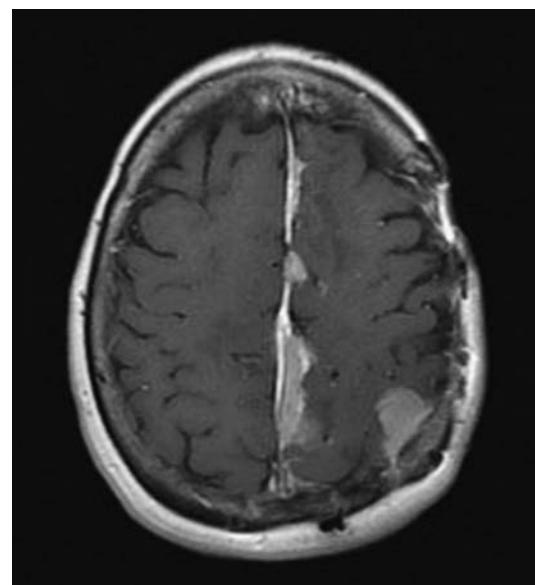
Postgadolinium T1 MRI demonstrating multiple meningiomas along the falx and left parietal cortex.
